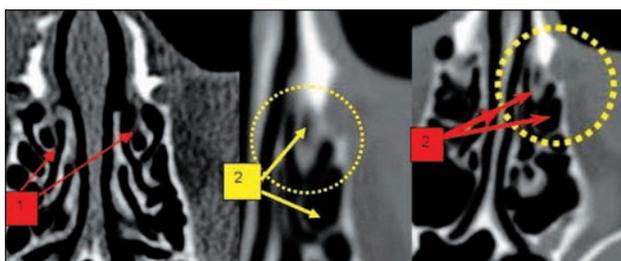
Paranasal sinuses CT scan, bone window, axial slices: 1. bilateral pneumatization of the uncinete process; 2. pneumatized left uncinete process associated with giant left ethmoid bulla
